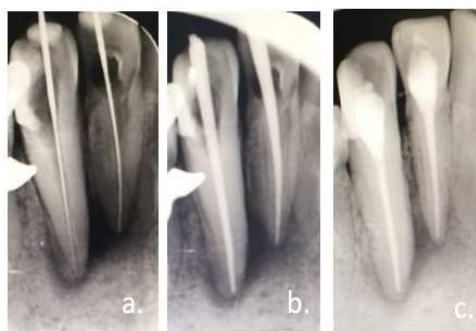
(a) Working length determination by initial file, (b) Master apical cone measurement, (c) Radiograph evaluation after obturation.
